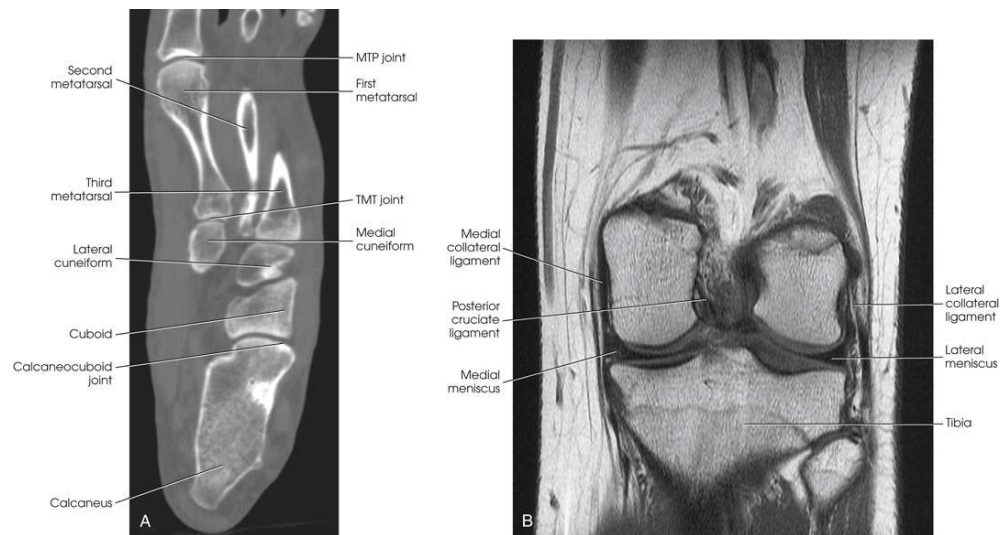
(A) Axial CT scan of foot and calcaneus. (B) MRI coronal plane of the knee joint. Joint spaces are clearly shown.
